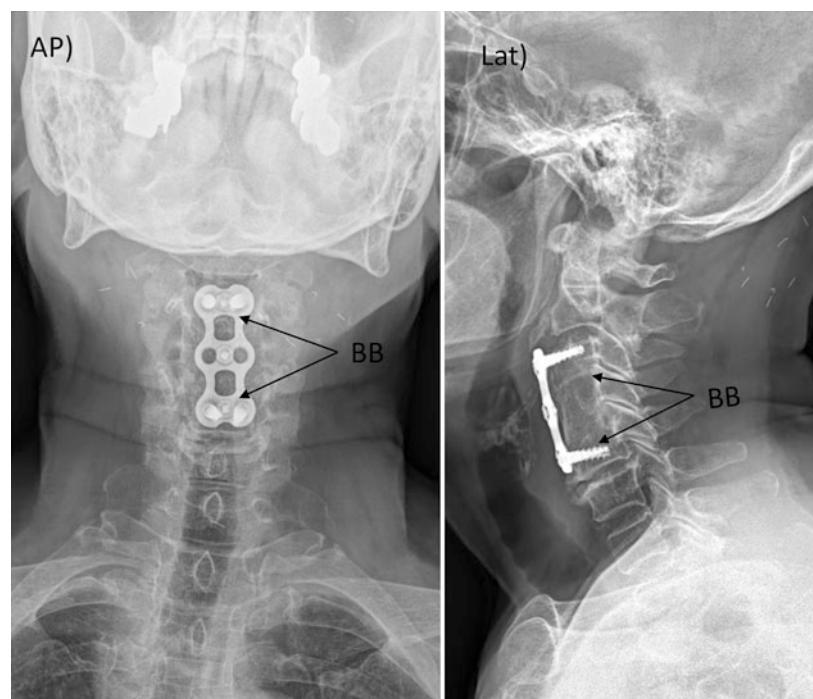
A 59-year old patient was surgically treated for fracture dislocation injury at C3 vertebrae after fall from height. Treatment of fracture was performed by a decompression through corpectomy and fusion using auto-iliac crest strut bone graft with cervical metal plate fixation spanning C3–4–5. On anterior-posterior (AP), lateral (L) radiographs taken at 3-year follow-up, a radio-dense bone bridge (black BB) was observed between upper and lower vertebral bodies (C3–C5 a solid bone unit). Note no radio-opaque gap between graft material and endplate of adjacent vertebral bodies
